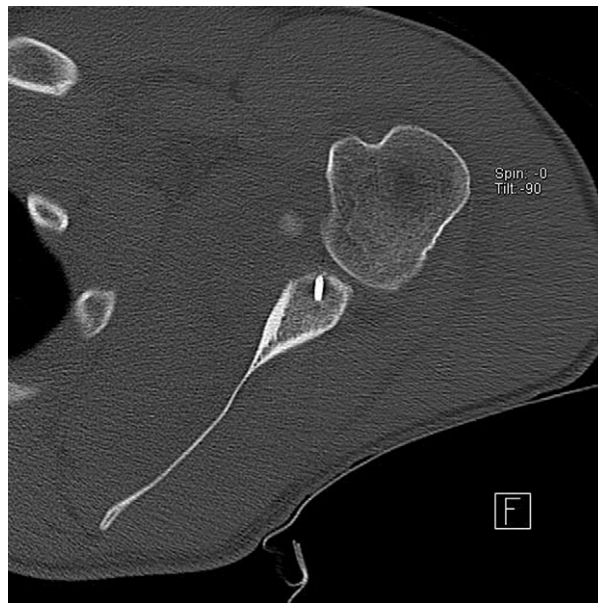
Axial computed tomography scan of inferior anchor. The glenoid rim was observed to have fractured distal to a well-fixed anchor.
